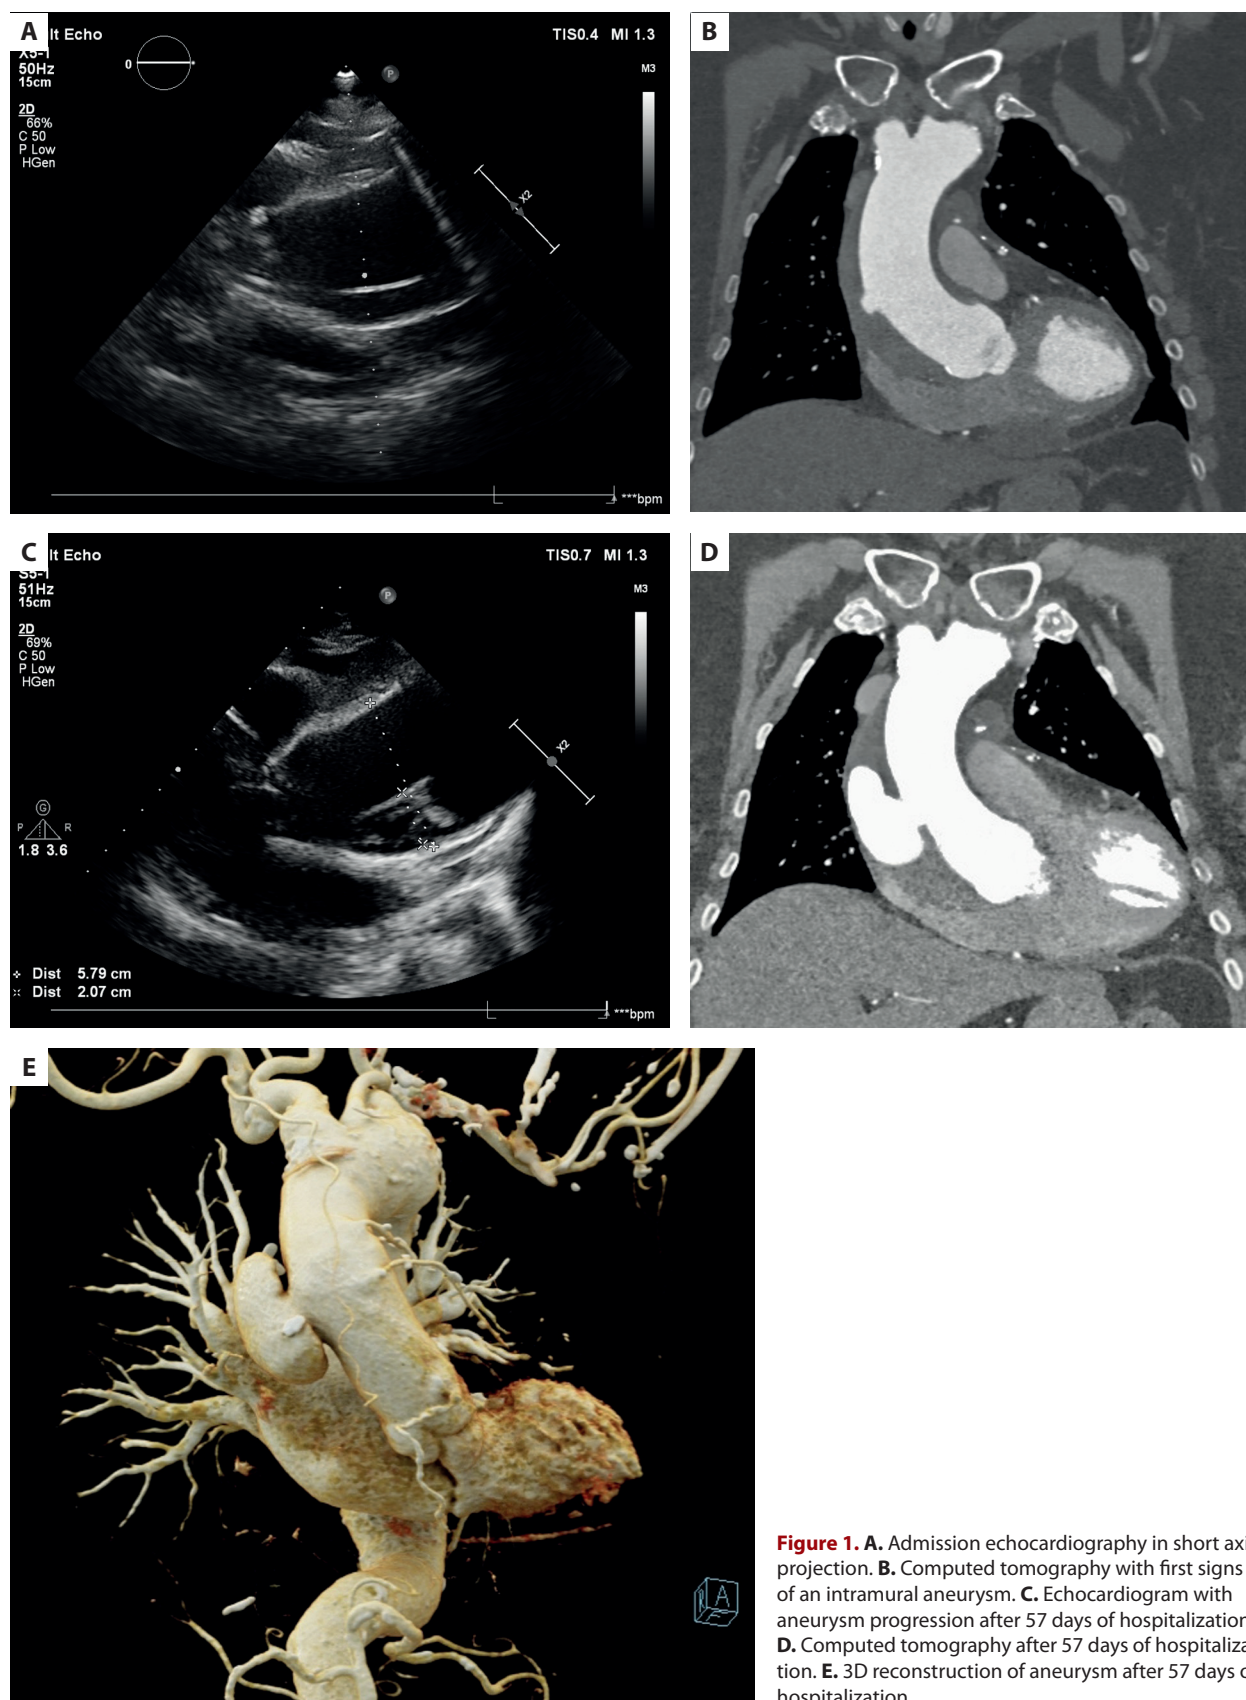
A. Admission echocardiography in short axis projection. B. Computed tomography with first signs of an intramural aneurysm. C. Echocardiogram with aneurysm progression after 57 days of hospitalization. D. Computed tomography after 57 days of hospitalization. E. 3D reconstruction of aneurysm after 57 days of hospitalization
